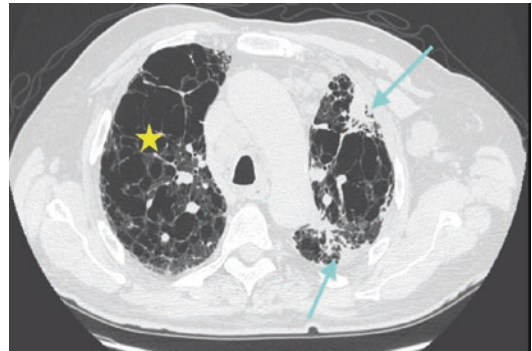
Asbestosis in a 70-year-old man who worked for 30 years in a shipyard. Axial image from a thin-section unenhanced CT scan (1.0-mm-thick sections) in lung window settings shows subpleural consolidation (arrow) referred to mesothelioma in the upper left lobe, with reticulation, honeycombing, and advanced pattern of emphysema (yellow star)
